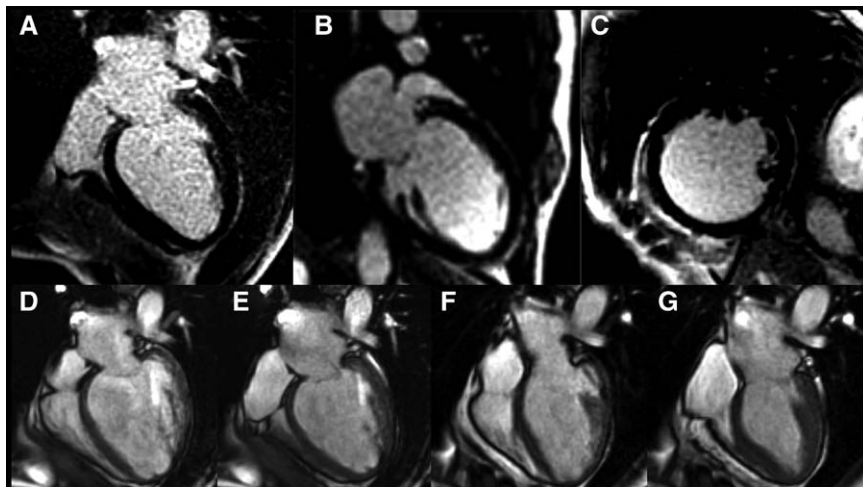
A 52-year-old woman with 8-month history of idiopathic dilated cardiomyopathy, left bundle branch block, and dyspnea on exertion (New York Heart Association class II). Baseline postcontrast cardiovascular magnetic resonance images in horizontal (A) and vertical long axis (B) and midventricular short axis (C) did not show late gadolinium enhancement. End-diastolic (D and F) and end-systolic (E and G) horizontal long-axis images at baseline (D and E; Movie I in the online-only Data Supplement) and follow-up (F and G; Movie II in the online-only Data Supplement) showing a reduction in left ventricular (LV) volumes (end-diastolic volume from 208 to 112 mL/m²; end-systolic volume from 169 to 61 mL/m²) and improvement in function (LV ejection fraction from 18% to 46%).
